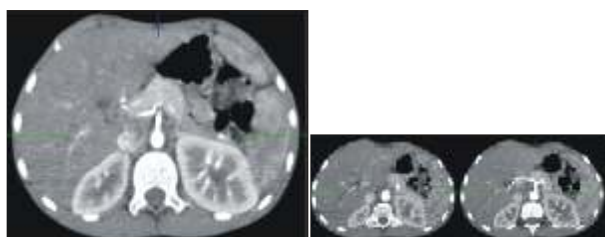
Axial and coronal CT angiography image shows Narrowing of caliber of bilateral renal arteries just after their origin.
